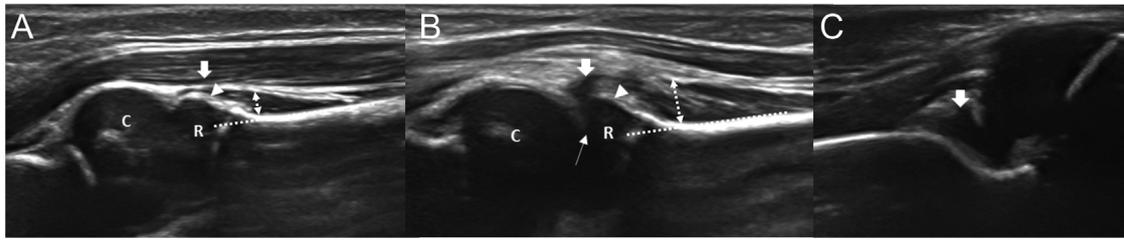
Ultrasonography examination is performed at the anterior portion of the radiocapitellar joint longitudinally.
